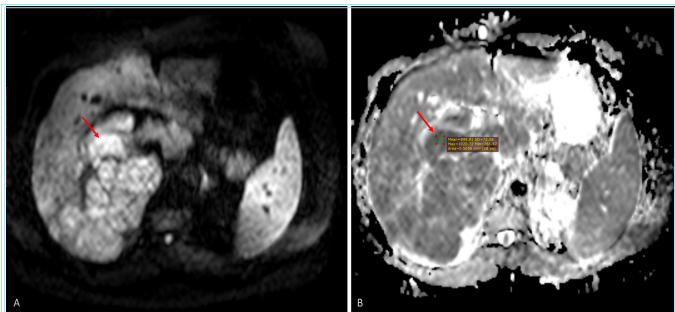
DWI (A) and ADC (B) images of a 46-year-old male patient with renal cell carcinoma metastasis in the liver. The lesion is localized in liver segment 7-8, appearing hyperintense on DWI and hypointense on ADC (arrow demonstrates an example ADC measurement)
